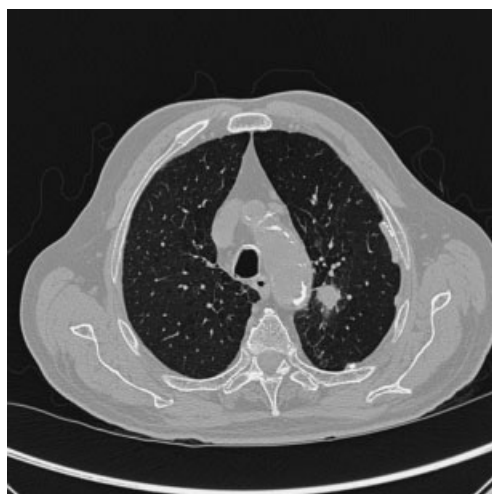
Chest computed tomography (CT). Chest CT shows speculated left upper lobe lung mass.
